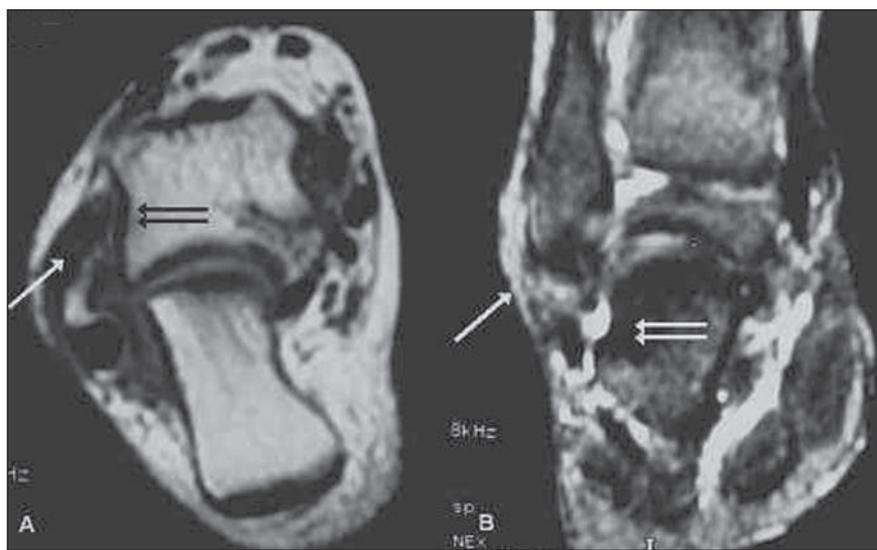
T1-weighted axial (A) and coronal, proton density with fat suppression (B) demonstrating isointense tissue in the anterolateral gutter (arrows) and minimal corresponding sclerosis on the lateral talar surface (double arrows) characterizing the impingement.
